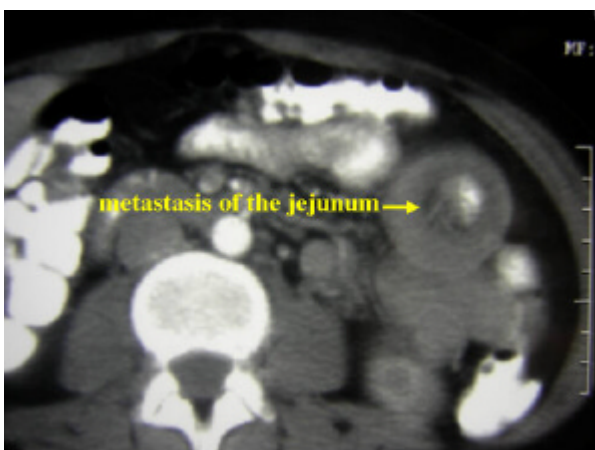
Abdominal CT scan of the metastasis in the jejunum. The almost concentric metastasis caused mild complaints of obstruction.
